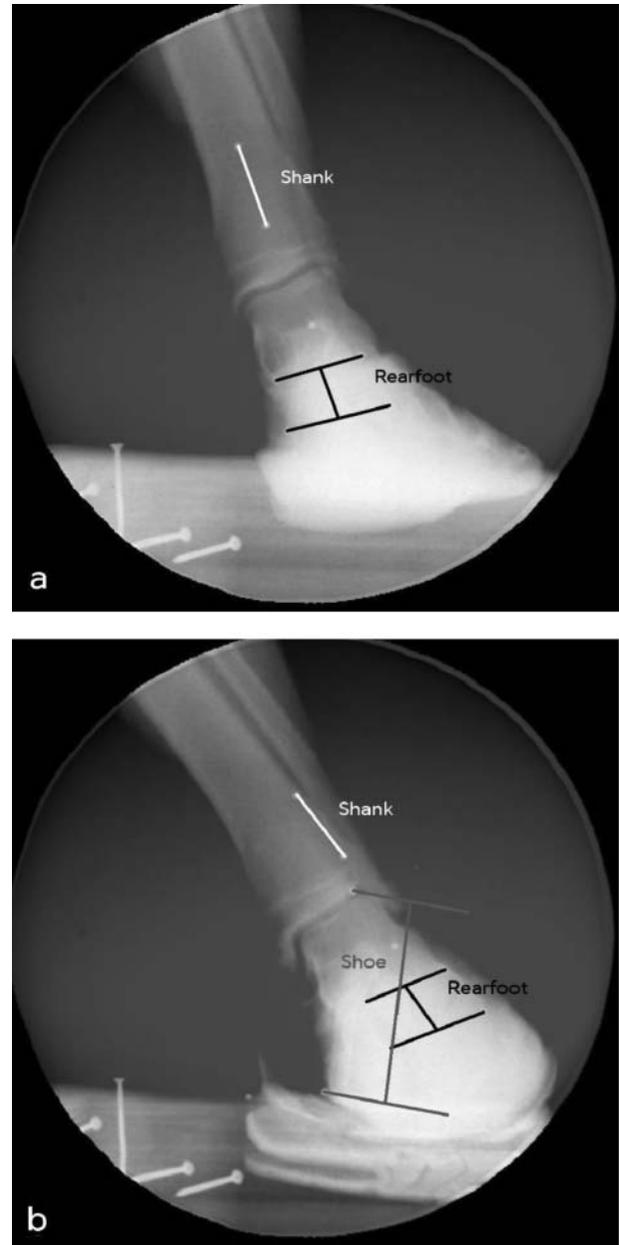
Representative x-ray images showing the angles measured based on the location of beads placed on the back of the shank, rearfoot, and shoe during cutting when barefoot (a) and shod (b).
